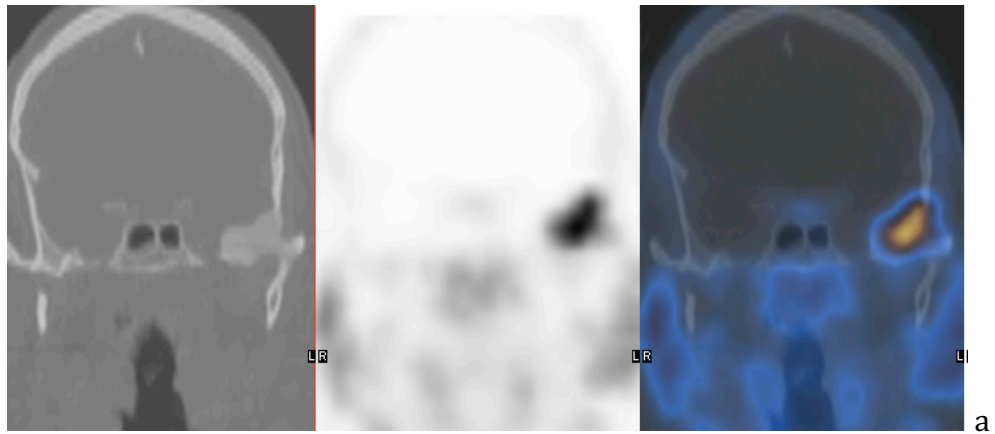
a - Coronal (low-dose CT, PET, and PET/CT) and b axial (low-dose CT and PET/CT) ^{18}F -FECH images showing an intensely avid area at the left skull base with ground glass appearances on low-dose CT. These findings are in keeping with fibrous dysplasia.
